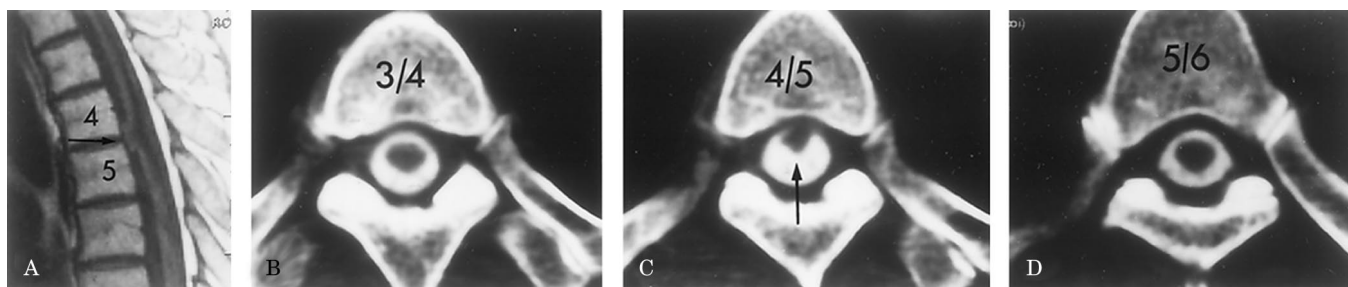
(A) Preoperative T1-weighted MRI (sagittal view) shows the ventral protrusion of the spinal cord as an abrupt ventral curve at the T4–5 level. (B, C, and D) Preoperative CT myelogram (axial view) demonstrates ventral displacement of the spinal cord at the T4–5 level without dorsal intradural cysts or tumors.
